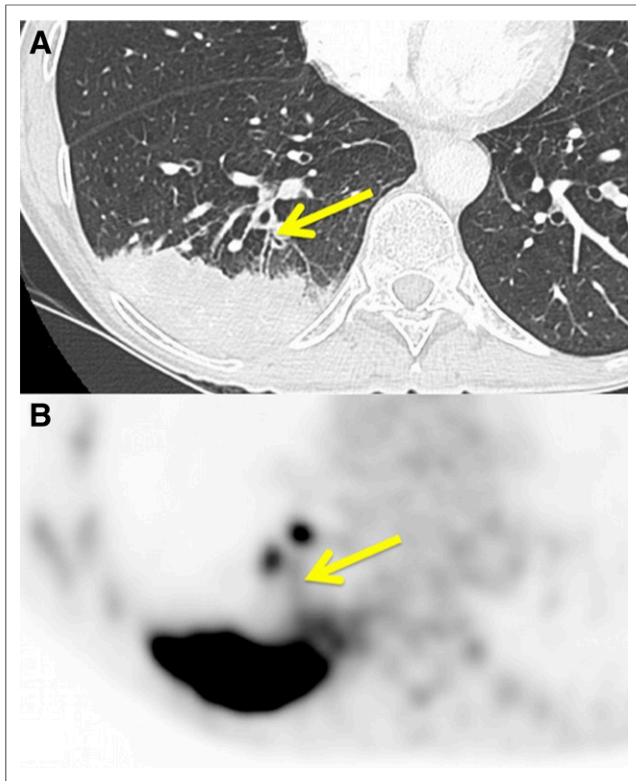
Case of 66-y-old woman referred for initial staging of inferior lobe pulmonary adenocarcinoma (stage IIIA, arrow). (A) HRCT shows positive peribronchovascular thickening sign. (B) ^{18}F -FDG PET/CT shows ^{18}F -FDG uptake higher than background in corresponding region, with SUV_{max} of 2.5 g/mL and SUV_{max} -to-background ratio of 3.6.
